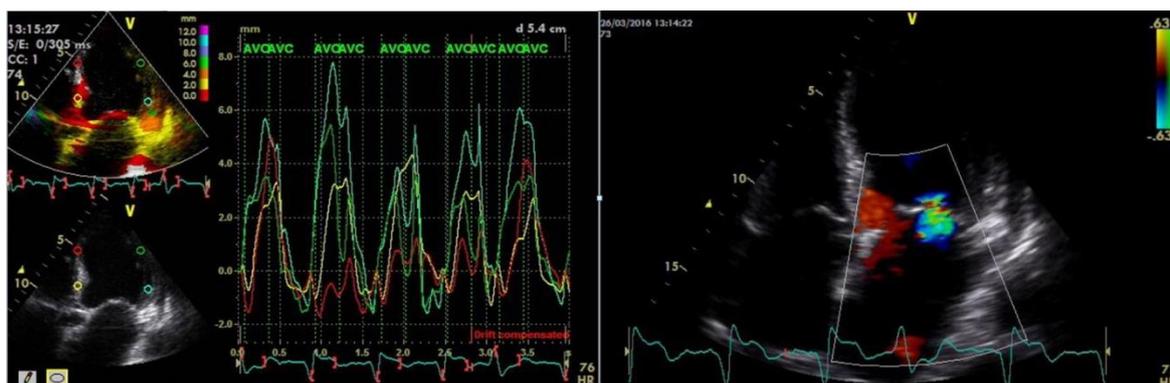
Transthoracic echocardiography. Tissue Doppler in apical four-chamber view with tissue tracking (left). Apical four-chamber view, mild mitral regurgitation (right)
